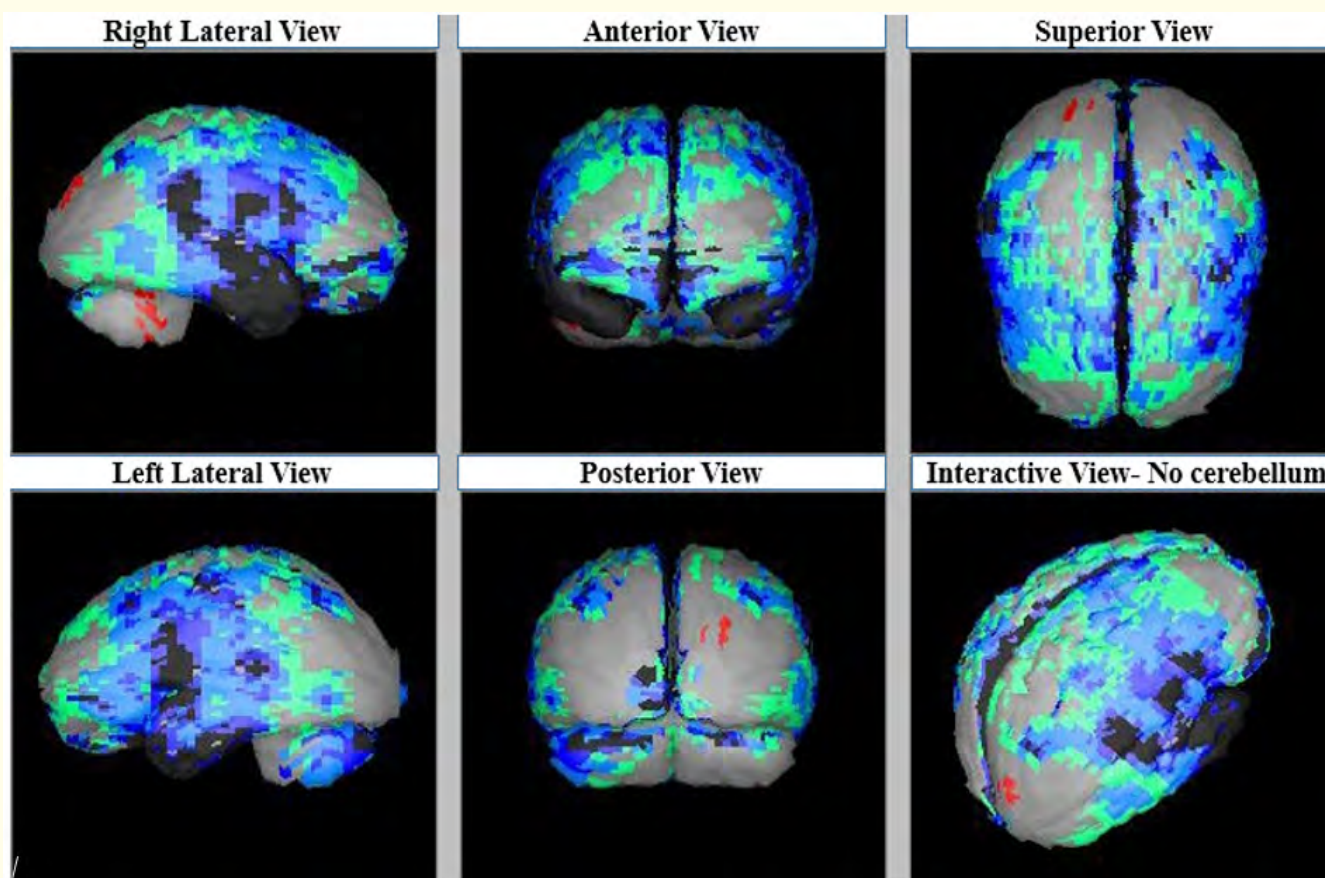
SPECT scan of ALS disease patient's before therapy showing hypoperfused regions.
